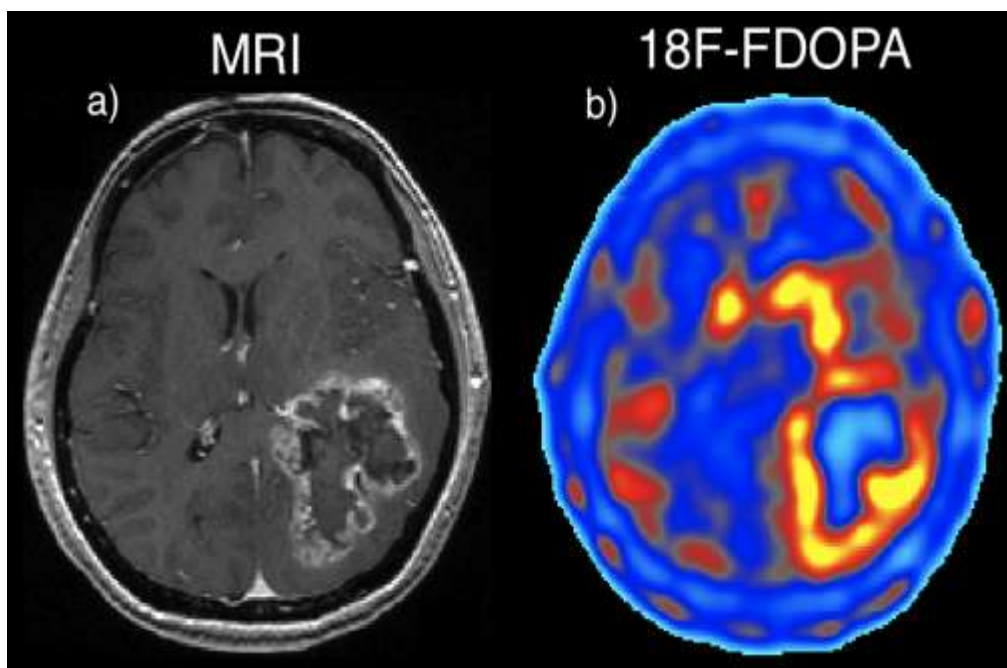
a) Contrast enhanced MRI and b) ^{18}F -FDOPA imaging of a primary high-grade glioma (grade IV – GBM).
